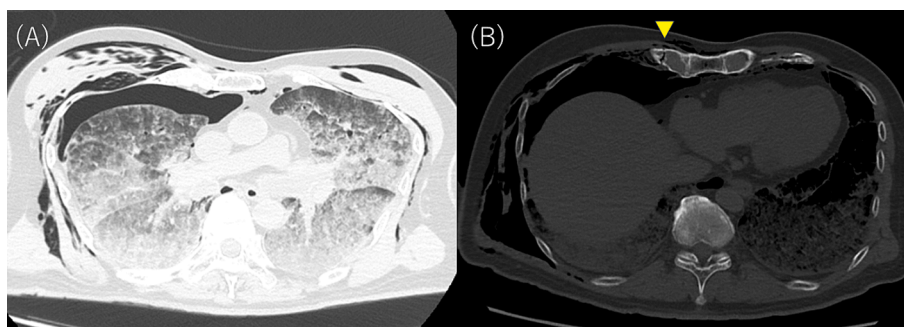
Example of chest compression complication during prolonged mechanical cardiopulmonary resuscitation (A) Computed tomography (CT) of lung window at the level of the pulmonary arteries, showing pneumothorax, mediastinal emphysema, and subcutaneous emphysema. (B) CT of soft tissue window at the level of the liver showing pneumothorax, mediastinal emphysema, subcutaneous emphysema, as well as costal cartilage fracture (yellow annotation).
